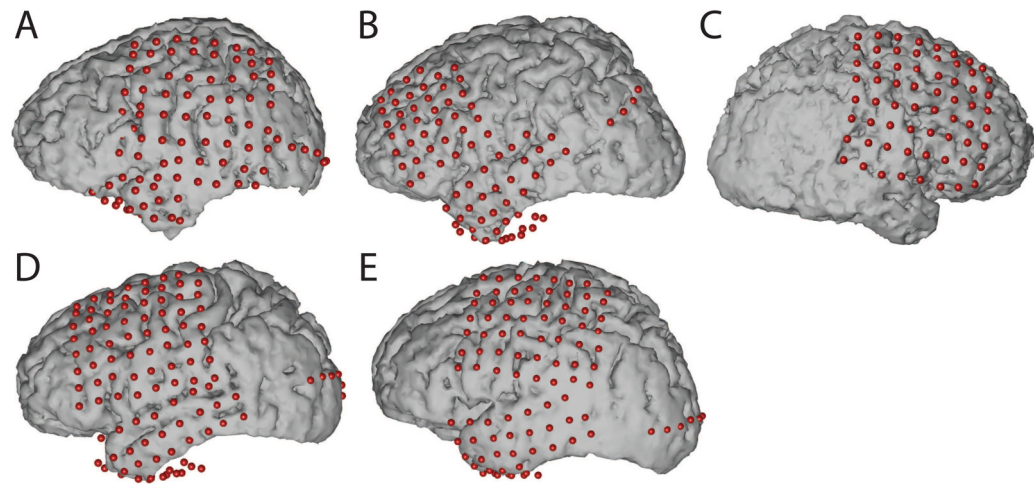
Locations of implanted grids on individual subject cortical models resulting from co-registration of pre-op MRI and post-op CT images.
